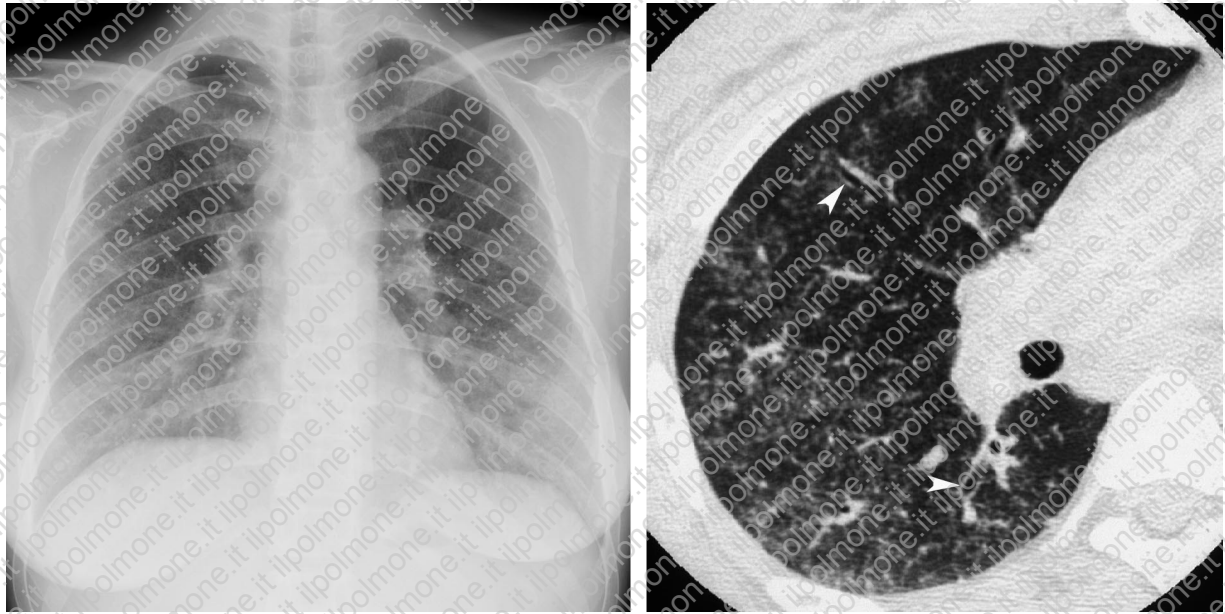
Pulmonary sarcoidosis in a 31-year-old woman. (a) Chest radiograph shows hazy ground-glass opacity with a lower lung predominance, both of which are unusual findings. (b) High-resolution chest CT scan shows widespread areas of ground-glass attenuation with reticulonodular hyperattenuating areas. Mild bronchiectasis is present peripherally (arrowheads).
